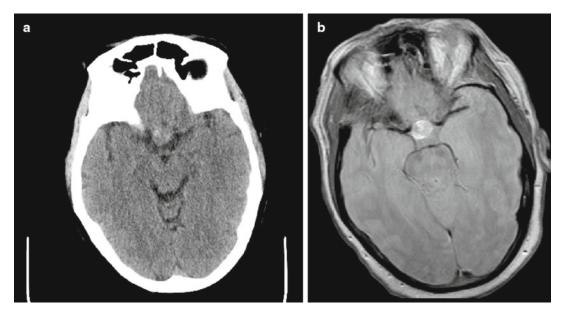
Pituitary apoplexy. Unenhanced CT (a) and MRI (b) demonstrate acute hemorrhage into a pituitary adenoma
